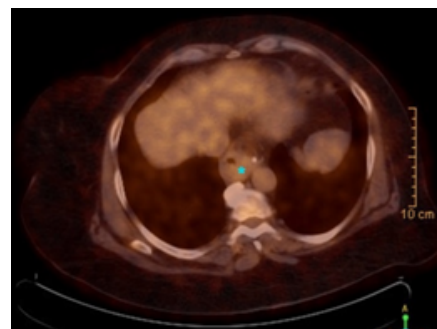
PET-CT, with asterisk showing almost complete resolution of the previously seen hypermetabolic gastroesophageal junction mass.
